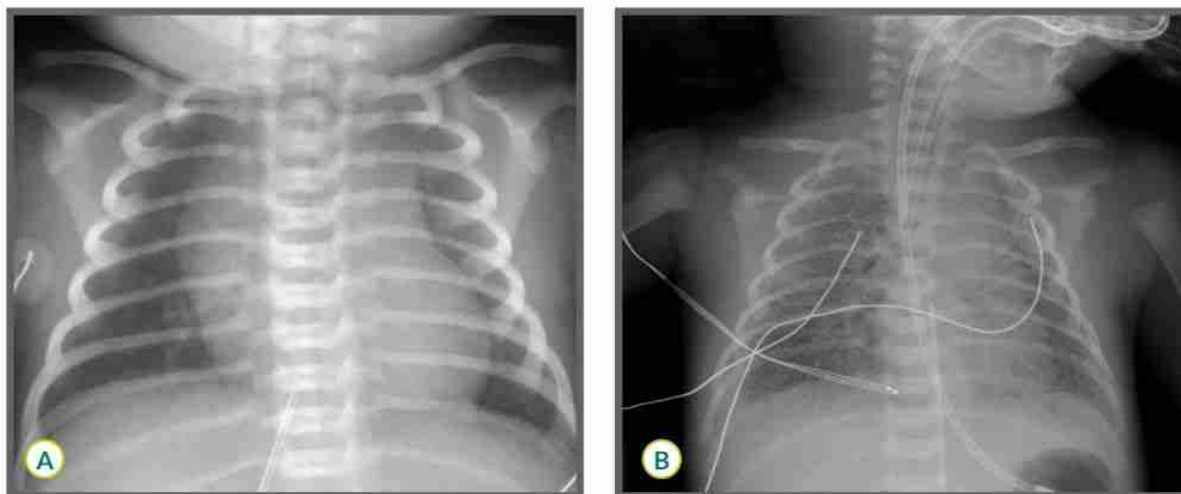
Neonatal chest radiographs: (A) normal, (B) pneumonia.
